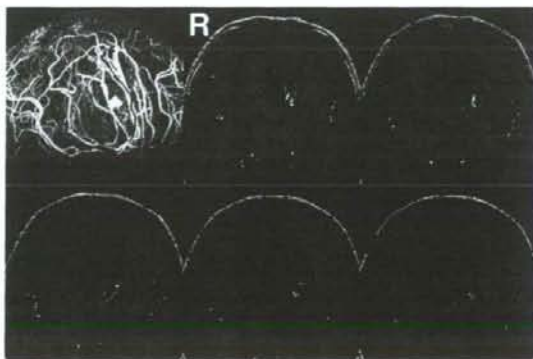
Case 3, a 29-year-old woman with transitional meningioma. The green line was drawn on the anterior cerebral artery (ACA) on the maximum intensity projection image in three-dimensional space and the location of the green line was shown simultaneously on axial spoiled gradient recalled magnetic resonance images as a red point. The A₂ and A₃ segments of bilateral ACAs were displaced and ran along the posterior part of the tumor.
